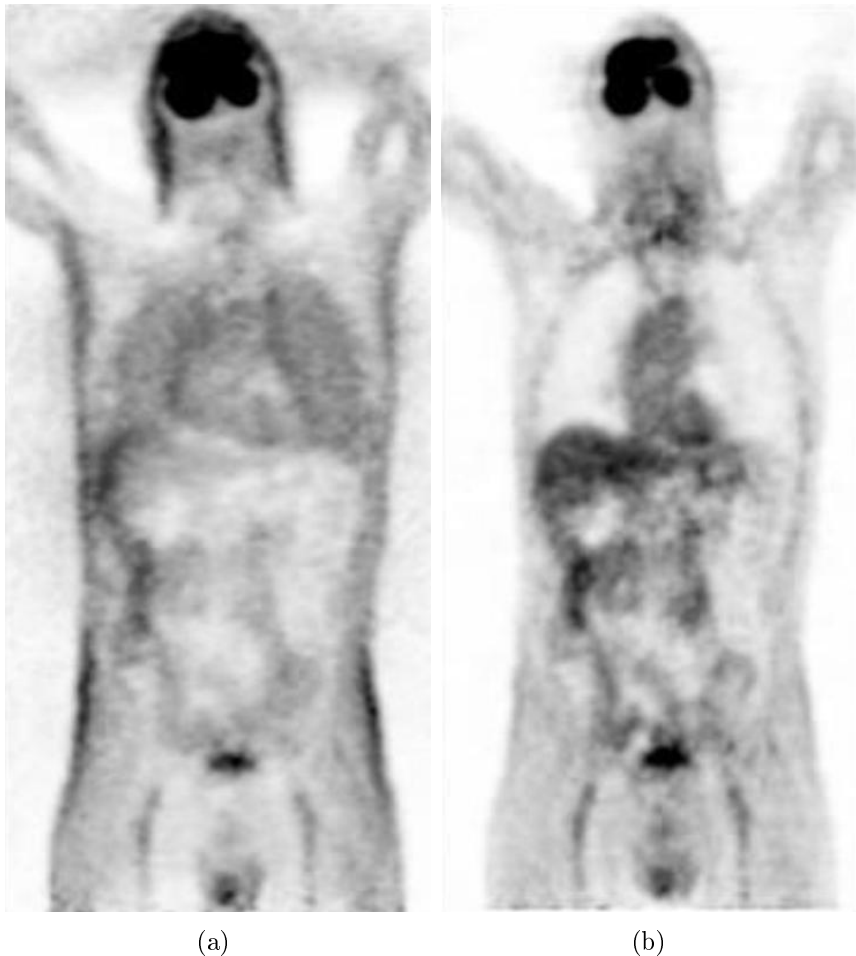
Coronal slice of a ^{18}F -FDG PET image reconstructed without (a) and with (b) attenuation correction. In non-attenuation corrected images, the activity distribution is distorted; among other effects, there is an increased contrast between the surface and inner structures as well as an erroneously high-count density in the lungs.
